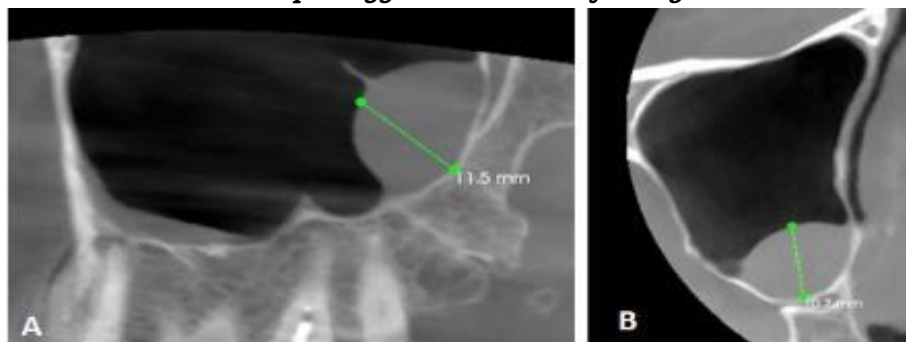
Comparative imaging of a mucous retention cyst in the right maxillary sinus. A. Coronal CBCT slice showing a dome-shaped soft tissue mass arising from the sinus floor, measuring 11.5mm. B. Sagittal CBCT image with vertical measurement of 10.7 mm, confirming its extension and rounded contour.
